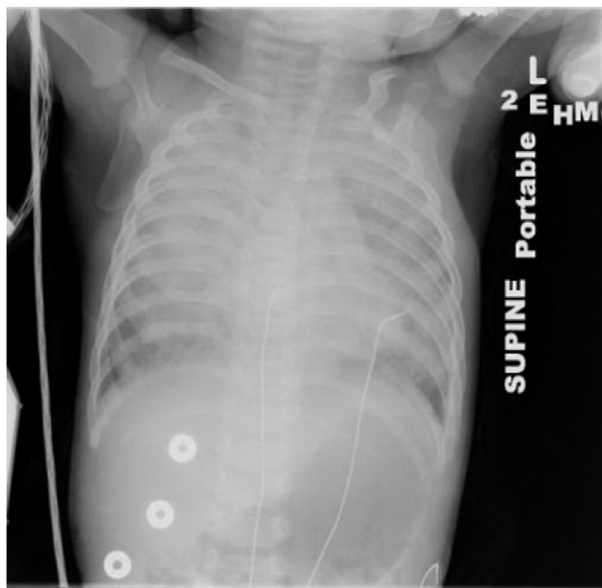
Chest radiograph obtained in the ED demonstrating bilateral infiltrates.
